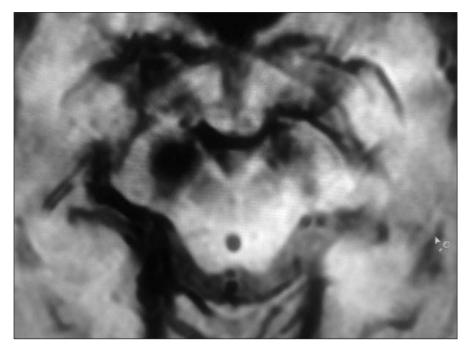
Brain MRI with SWI regimen. Blurred boundaries of nigrosome 1 of the substantia nigra are seen
